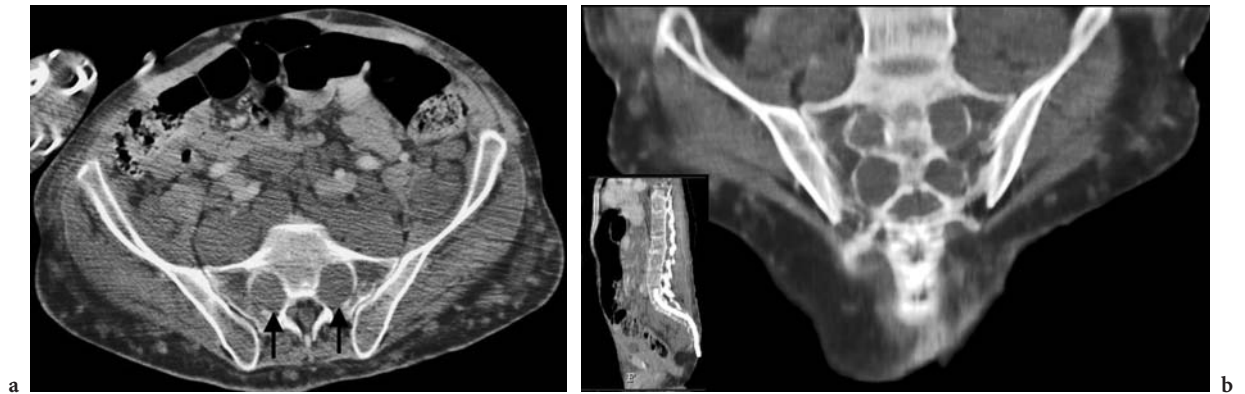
Neurofibromatosis, incidentally detected on a CT scan of the abdomen and pelvis which was performed for unrelated reasons. a There is enlargement of the neural foramina in the sacrum (arrows) on this axial CT image. There are innumerable masses anterior to the sacrum and iliac bones, as well as in the subcutaneous tissues. b Coronal CT reformatted
